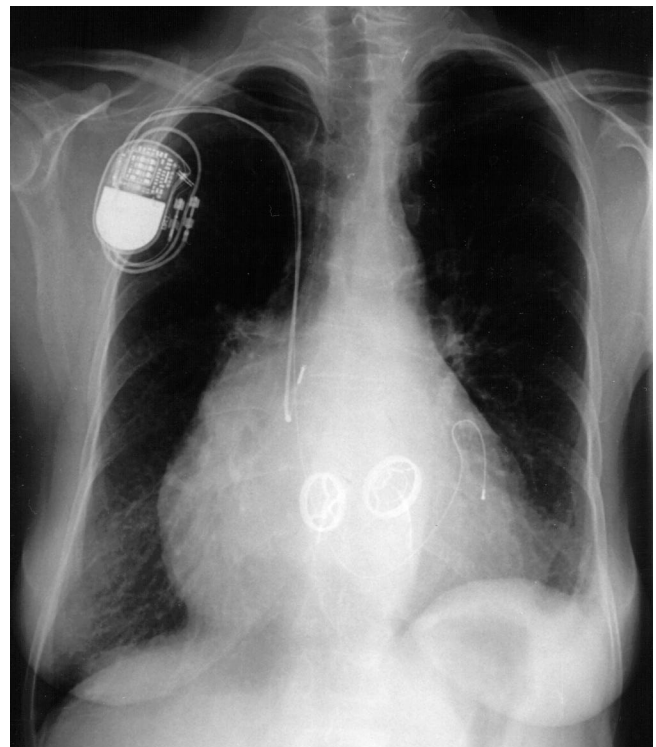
X-ray from the anterior view, ventricular electrode ends just below the valvular plane.
